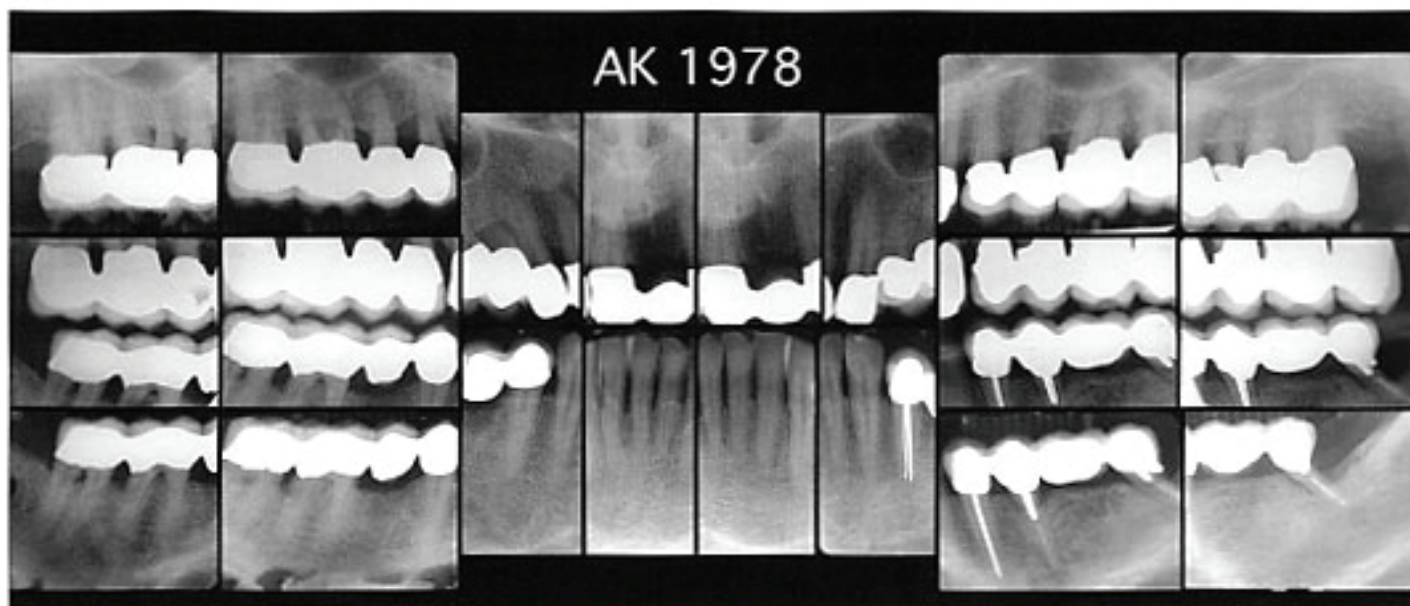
Full-mouth post-treatment X-rays, 1978.
